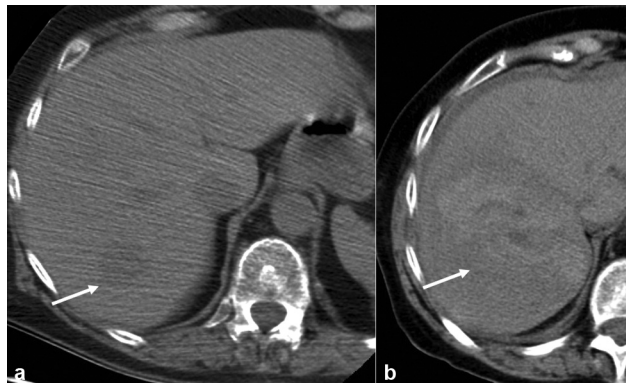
(a) Axial unenhanced preliminary CT scan of the liver obtained at the time of RFA which demonstrates a colorectal metastasis (white arrow). (b) Axial unenhanced CT scan obtained immediately after RFA which demonstrates an intraparenchymal hematoma.
